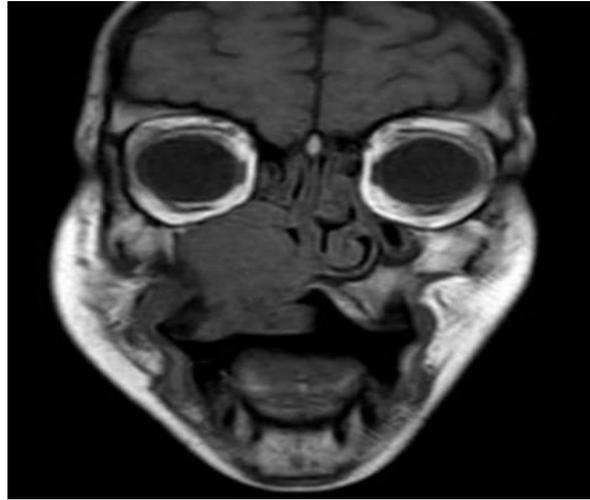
MRI maxillofacial (coronal view) of patient with right maxillary synovial sarcoma extending intranasal & destroying the infraorbital wall.
